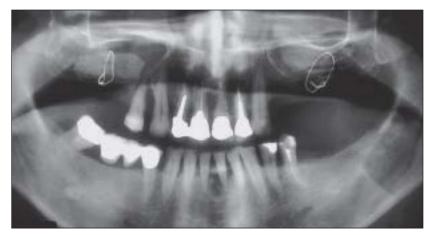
Panoramic radiograph showing bilateral sinus lift with particulated bone reconstructing the alveolar process with bone graft. The bone grafts are secured with wires, one on each side.
